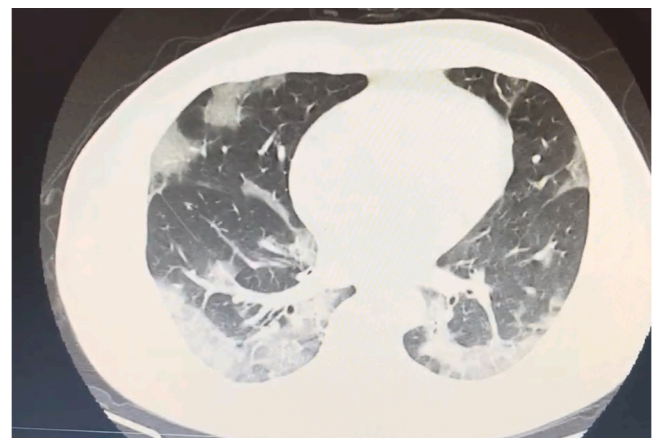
The image shows an axial chest computed tomography scan, revealing extensive bilateral ground-glass opacities, predominantly in the peripheral regions. These findings are suggestive of viral lung involvement, consistent with a typical pattern observed in patients with COVID-19.
